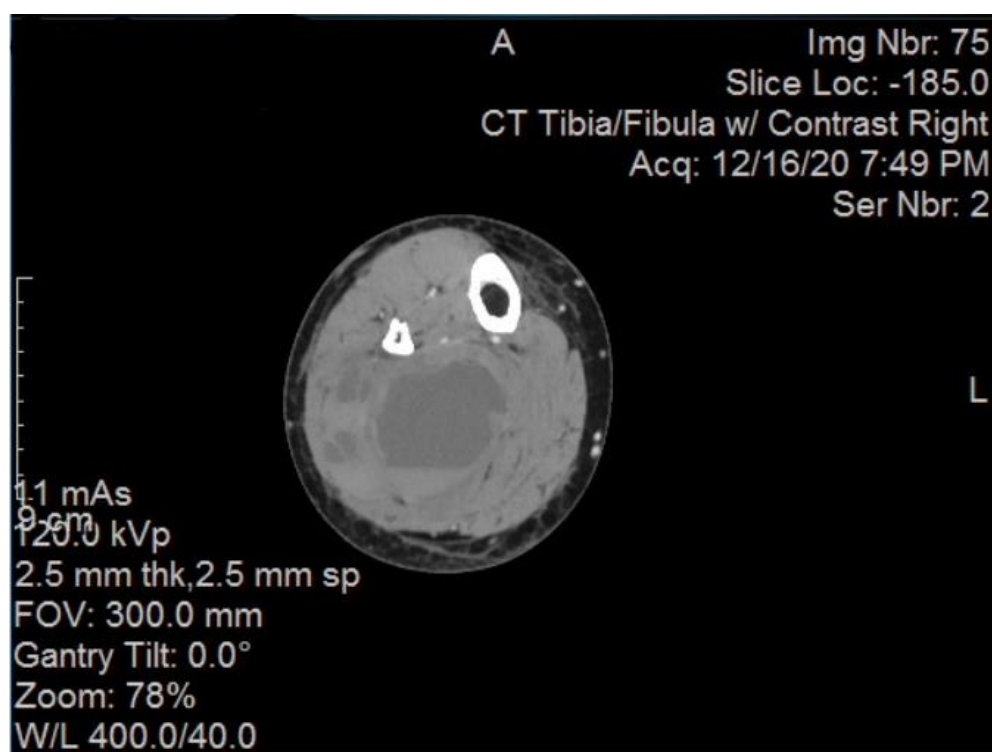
Contrast-enhanced CT of right tibia and fibula shows hematoma in the deep posterior muscle compartment on the same day that right lower extremity ultrasound revealed thrombi in the right common femoral vein, right deep femoral vein, and right femoral vein.
